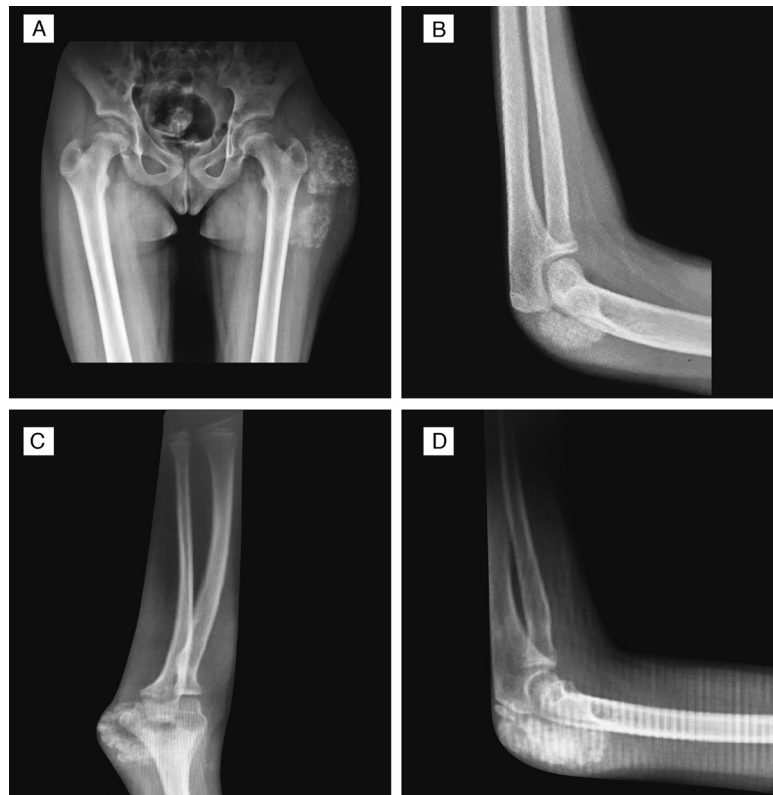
Radiographic findings in our two patients. Two giant radio-opaque soft tissue masses around the left femur neck of Case 1 in anteroposterior view (A). Lateral view of the left elbow of Case 1, revealing subcutaneous calcifications (B). Anteroposterior view of upper extremities shows a radio-opaque mass around the elbow joint of Case 2 (C). A subcutaneous calcified mass behind the olecranon is identified in a lateral view of the left elbow (D)
